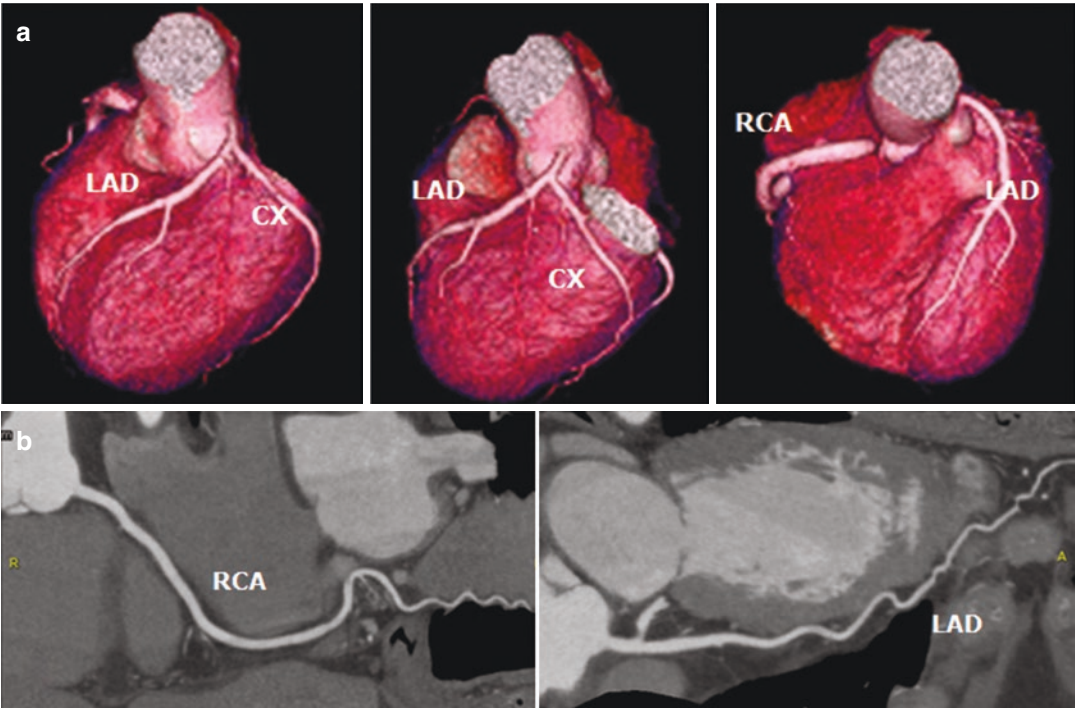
Normal CT coronary angiography with no atheromatous plaques (a). Three-dimensional volume rendering technique and (b) maximum intensity projection
